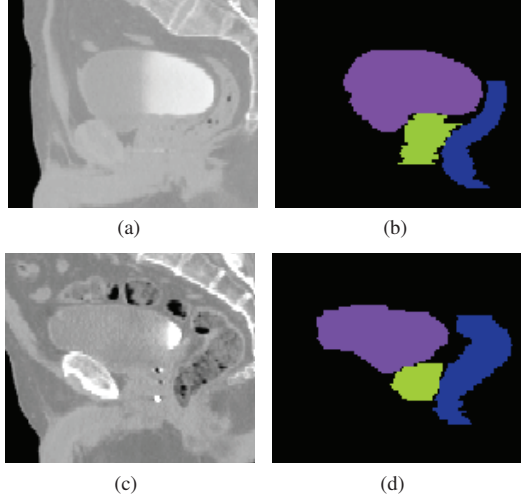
Example of two CT sagittal views ((a) individual and (c) template) with the delineated organs ((b) and (d)): prostate (green), bladder (mauve) and rectum (blue)
